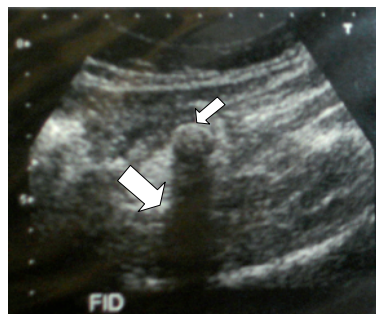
Ultrasonography of the patient, showing fecalith (smaller arrow) in the right iliac fossa. The larger arrow shows the acoustic shadow of the dense material.
